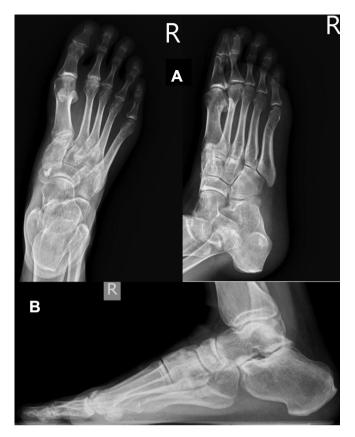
Plain radiographs taken 4 years after the injury. (A) Antero-posterior and oblique radiographs reveal no degenerative osteoarthritis of the midfoot, no osteonecrosis of the navicular bone graft substitutes *in situ*, and mild collapse of the secondary metatarsal head. (B) Full weight-bearing lateral radiograph reveals preservation of the medial arch and congruity of the naviculocuneiform joint without degenerative osteoarthritis or collapse.
